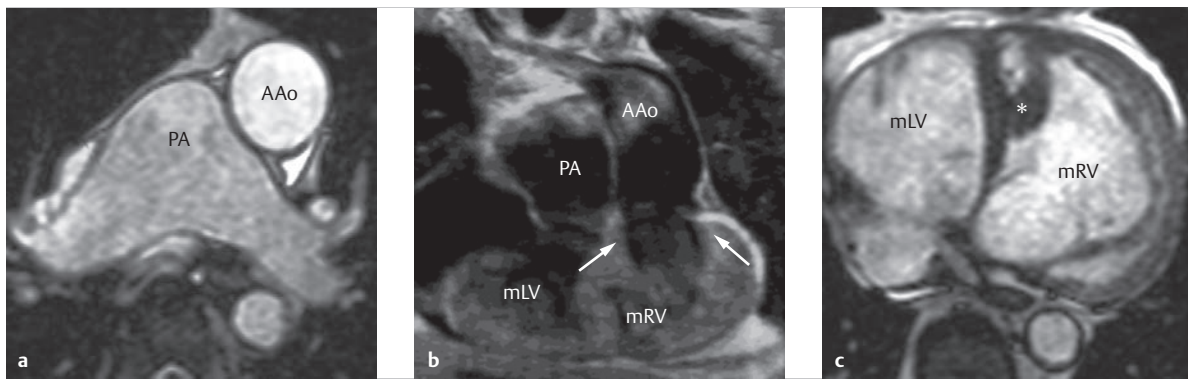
L-TGA. MRI of a 40-year-old, previously asymptomatic male patient with ccTGA.
